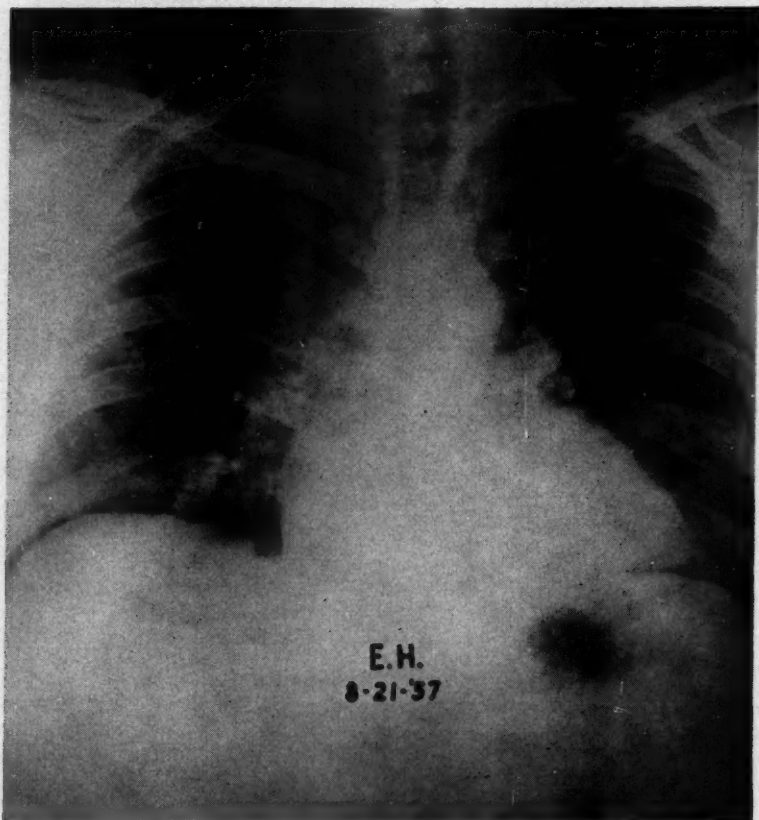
Repeat chest x-ray of case 1 taken about one year after onset. Marked clearing is present, but densities are still apparent in both lung fields and the hilar nodes are still enlarged.
